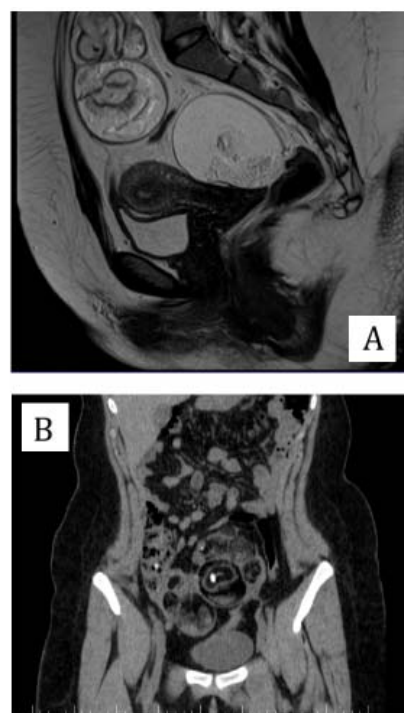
Migration of the ovarian formations from the pelvic cavity into the abdominal cavity, due to the high size and compression on the bladder. (A) MRI image, sagittal section. (B) CT image, frontal section.
